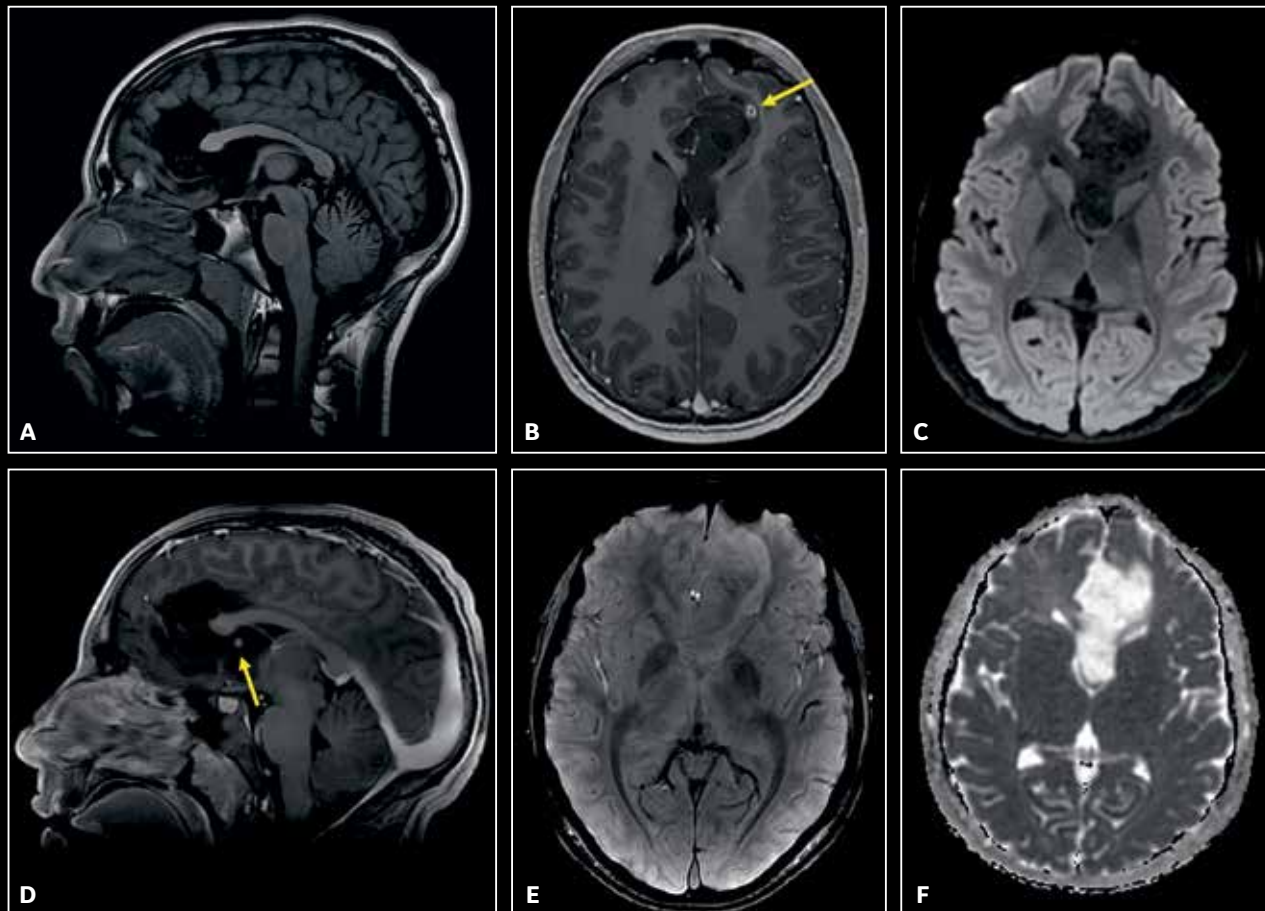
Additional conventional sequences. (A) Sagittal T1; (B) Axial post-contrast FSPGR; (C) DWI; (D) Sagittal reconstruction post-contrast FSPGR; (E) SWAN; and (F) ADC map. Areas of nodular and ring-like enhancement can be clearly depicted on post-contrast FSPGR (B, D, yellow arrows). (E) No coarse calcifications or blood products can be seen on SWAN. (C, F) Tumor diffusion was facilitated.
